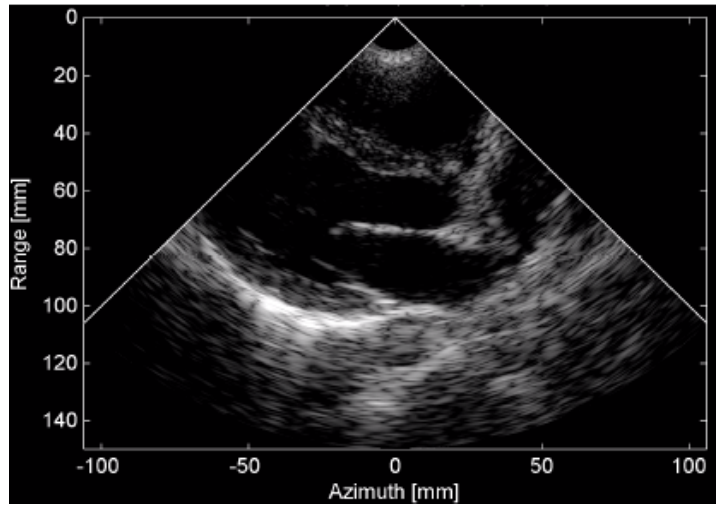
Parasternal long axis view of a heart. Reproduced from (Tong *et al.*, 2019) with permission under the CC-BY 4.0 licence.
